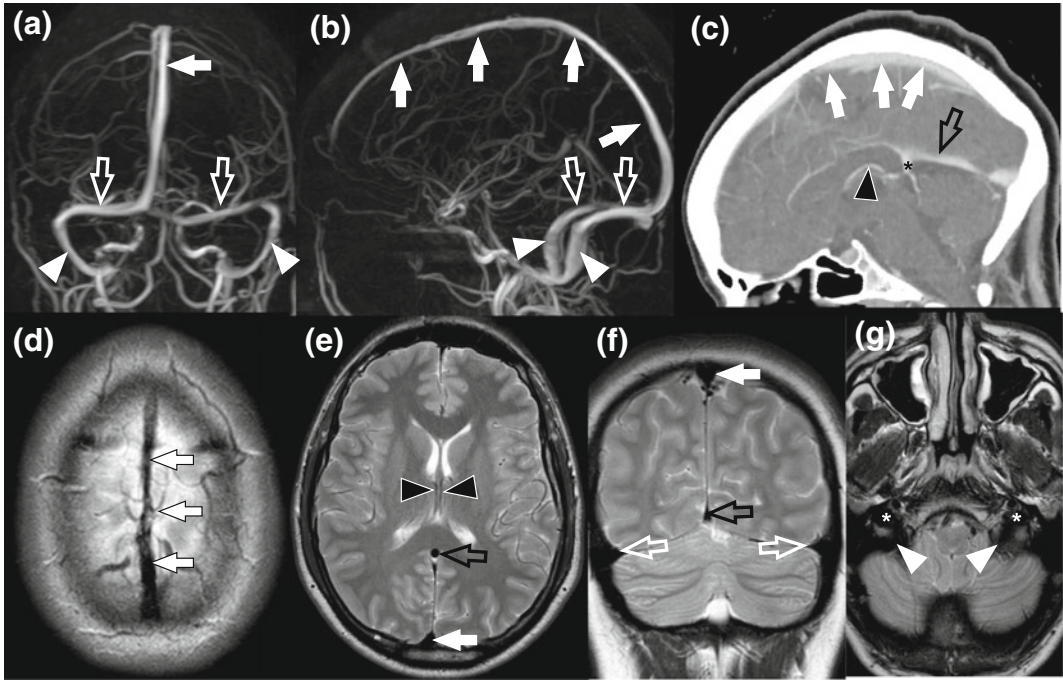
Cerebral venous system. Phase contrast MR venogram (a), AP maximum intensity projection (b), lateral maximum intensity projection (c), sagittal CT venogram (d, e, g), axial T2 weighted images (f), coronal T2 weighted image. *Solid white arrow* Superior sagittal
